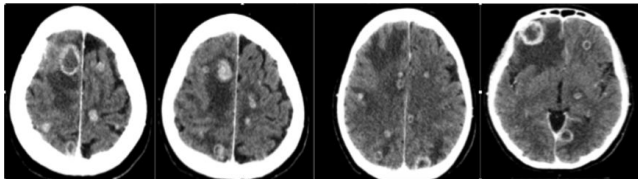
CT brain at 2 weeks after stopping Crizotinib.
